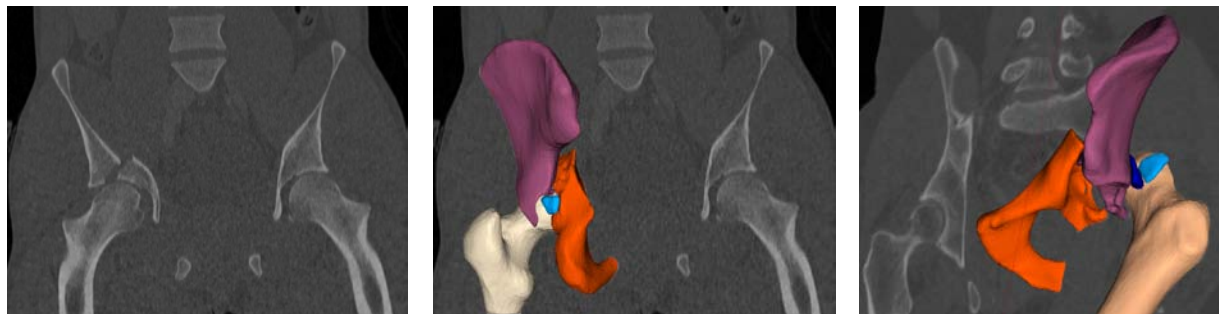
Example of transverse + posterior wall fracture of the acetabulum (left: CT image only; middle: along with the reconstructed 3D model). Right: a more complex case with two comminutive fragments and a dislocation of the femoral head.
